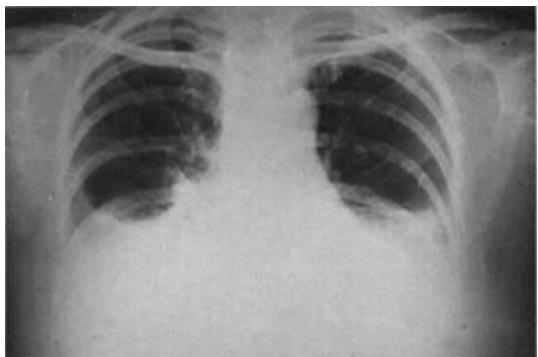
Complications following neck dissection: bilateral chylothorax. Roentgenogram showing fluid in both pleural cavities. Thoracentesis yielded large amounts of chyle. This phenomenon is additional evidence that mediastinal emphysema may occur during neck dissection; the air may rupture through the mediastinal pleura and produce pneumothorax (homolateral, contralateral, or bilateral)—a relatively serious postoperative complication.
